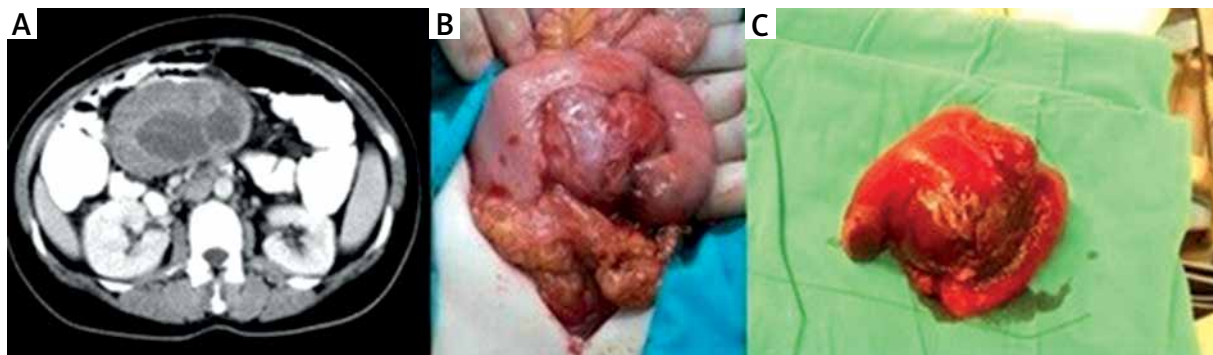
First operation. A – CT findings; hypodense lesion 9.5 × 8 × 7 cm in size with smooth borders, localised in the prox. small intestine’s mesenteric root, attacking the neighbouring loop. B – Intraoperative findings; tumorous mass originating from the proximal jejunal meso surrounding the jejunal serosa and invading the omentum. C – The mass after resection. Deformations related to jejunum invasion explaining the subileus picture (the omentum was removed from the piece for the photograph)
